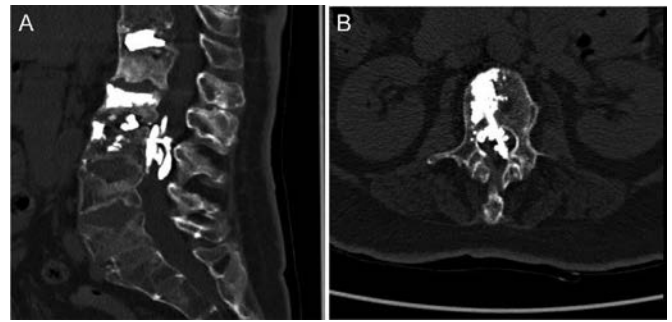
Preoperative sagittal (A) and transverse (B) computed tomography scans show that the bone cement penetrated the spinal canal along the puncture channel, occupying almost the entire L2/L3 level of the spinal canal, with noticeable spinal cord compression.
